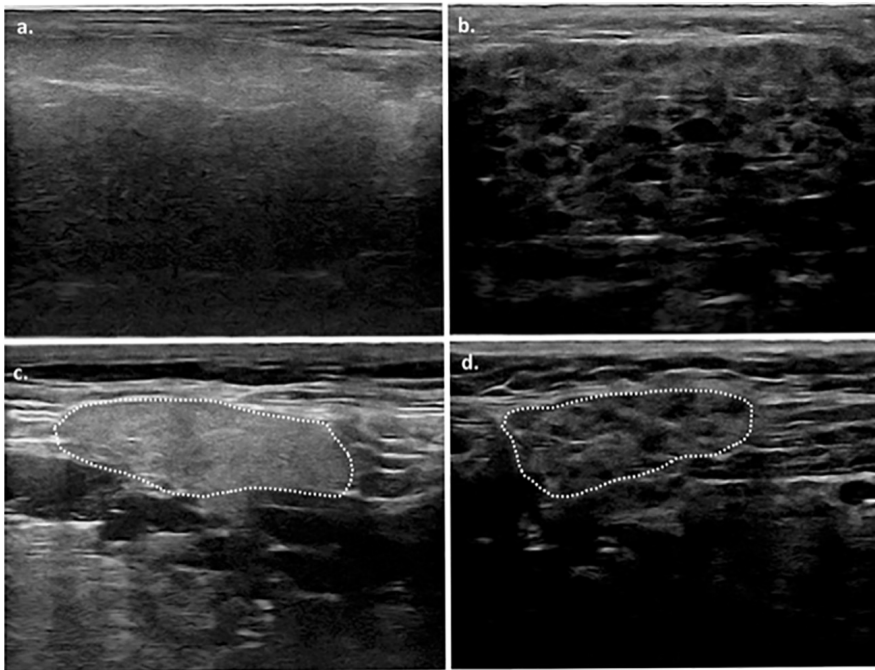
Representative ultrasonographic images of the major salivary glands: a. parotid gland with normal echotexture; b. parotid gland with echotexture corresponding to SjD; c. submandibular gland with normal echotexture; d. submandibular gland with echotexture corresponding to SjD.
